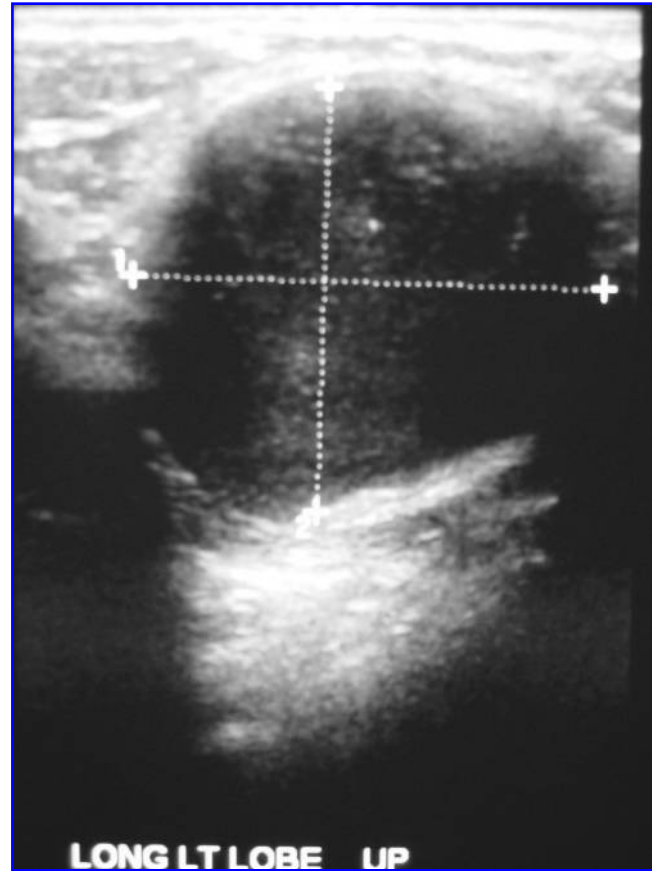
Thyroid ultrasound image on 1 year follow-up study (right prior to surgery) showing that left superior thyroid mass increased in size.
